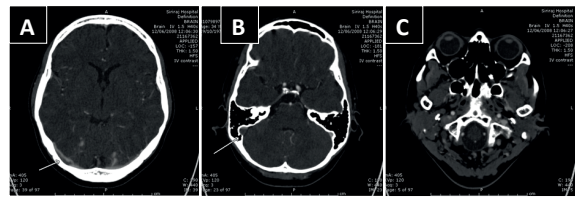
A 34-year-old female presented with symptoms of severe headache, blurred vision with nausea and vomiting for 4 days. She had been taking oral contraceptive pills for 26 years. The physical examination on admission revealed good consciousness with GCS of 15. The physical examination on admission revealed papilledema. An emergency CT of the brain was performed with the result showing long segment of occlusion of right transverse-sigmoid sinus (A-B) down to right internal jugular vein (C). The diagnosis of CVST right transverse sinus, right sigmoid sinus and right internal jugular vein was confirmed. Pretreatment mRS score = 2, then after anticoagulant therapy was given, posttreatment mRS score = 1 good outcome.
